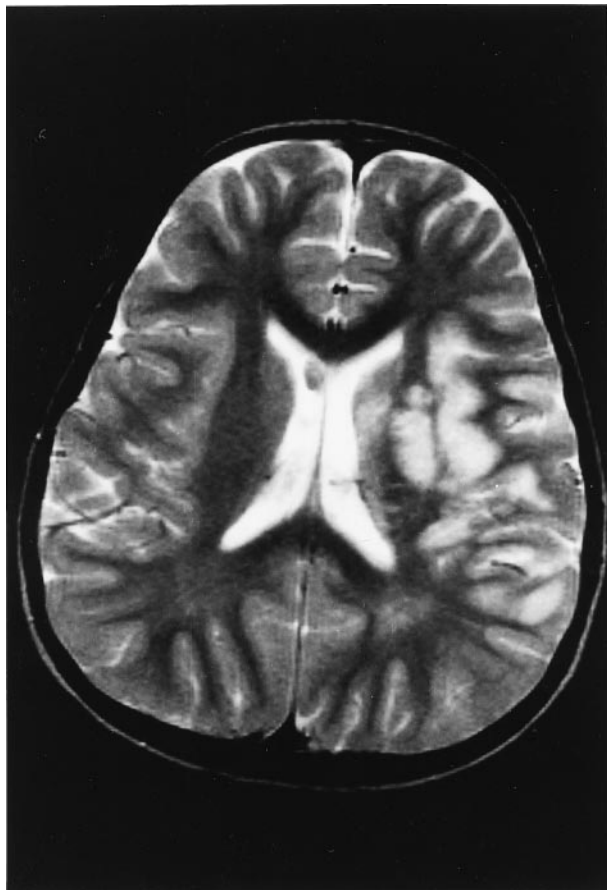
Magnetic resonance image (T_2 -weighted image, TE = 90 ms, TR = 3,506 ms) demonstrating increased signal intensity over the left putamen, left globus pallidus, left insular region, left frontal lobe, and the parietal area.
